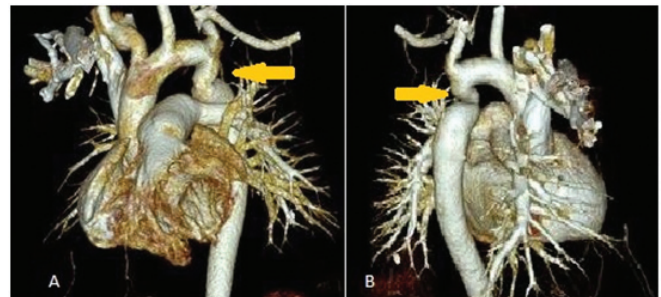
CT Aortogram – 3-Dimensional Volume rendering technique (3D VRT) image- Anterior (A) and posterior (B) views with arrow showing tortuous kinking of aorta distal to left subclavian artery
